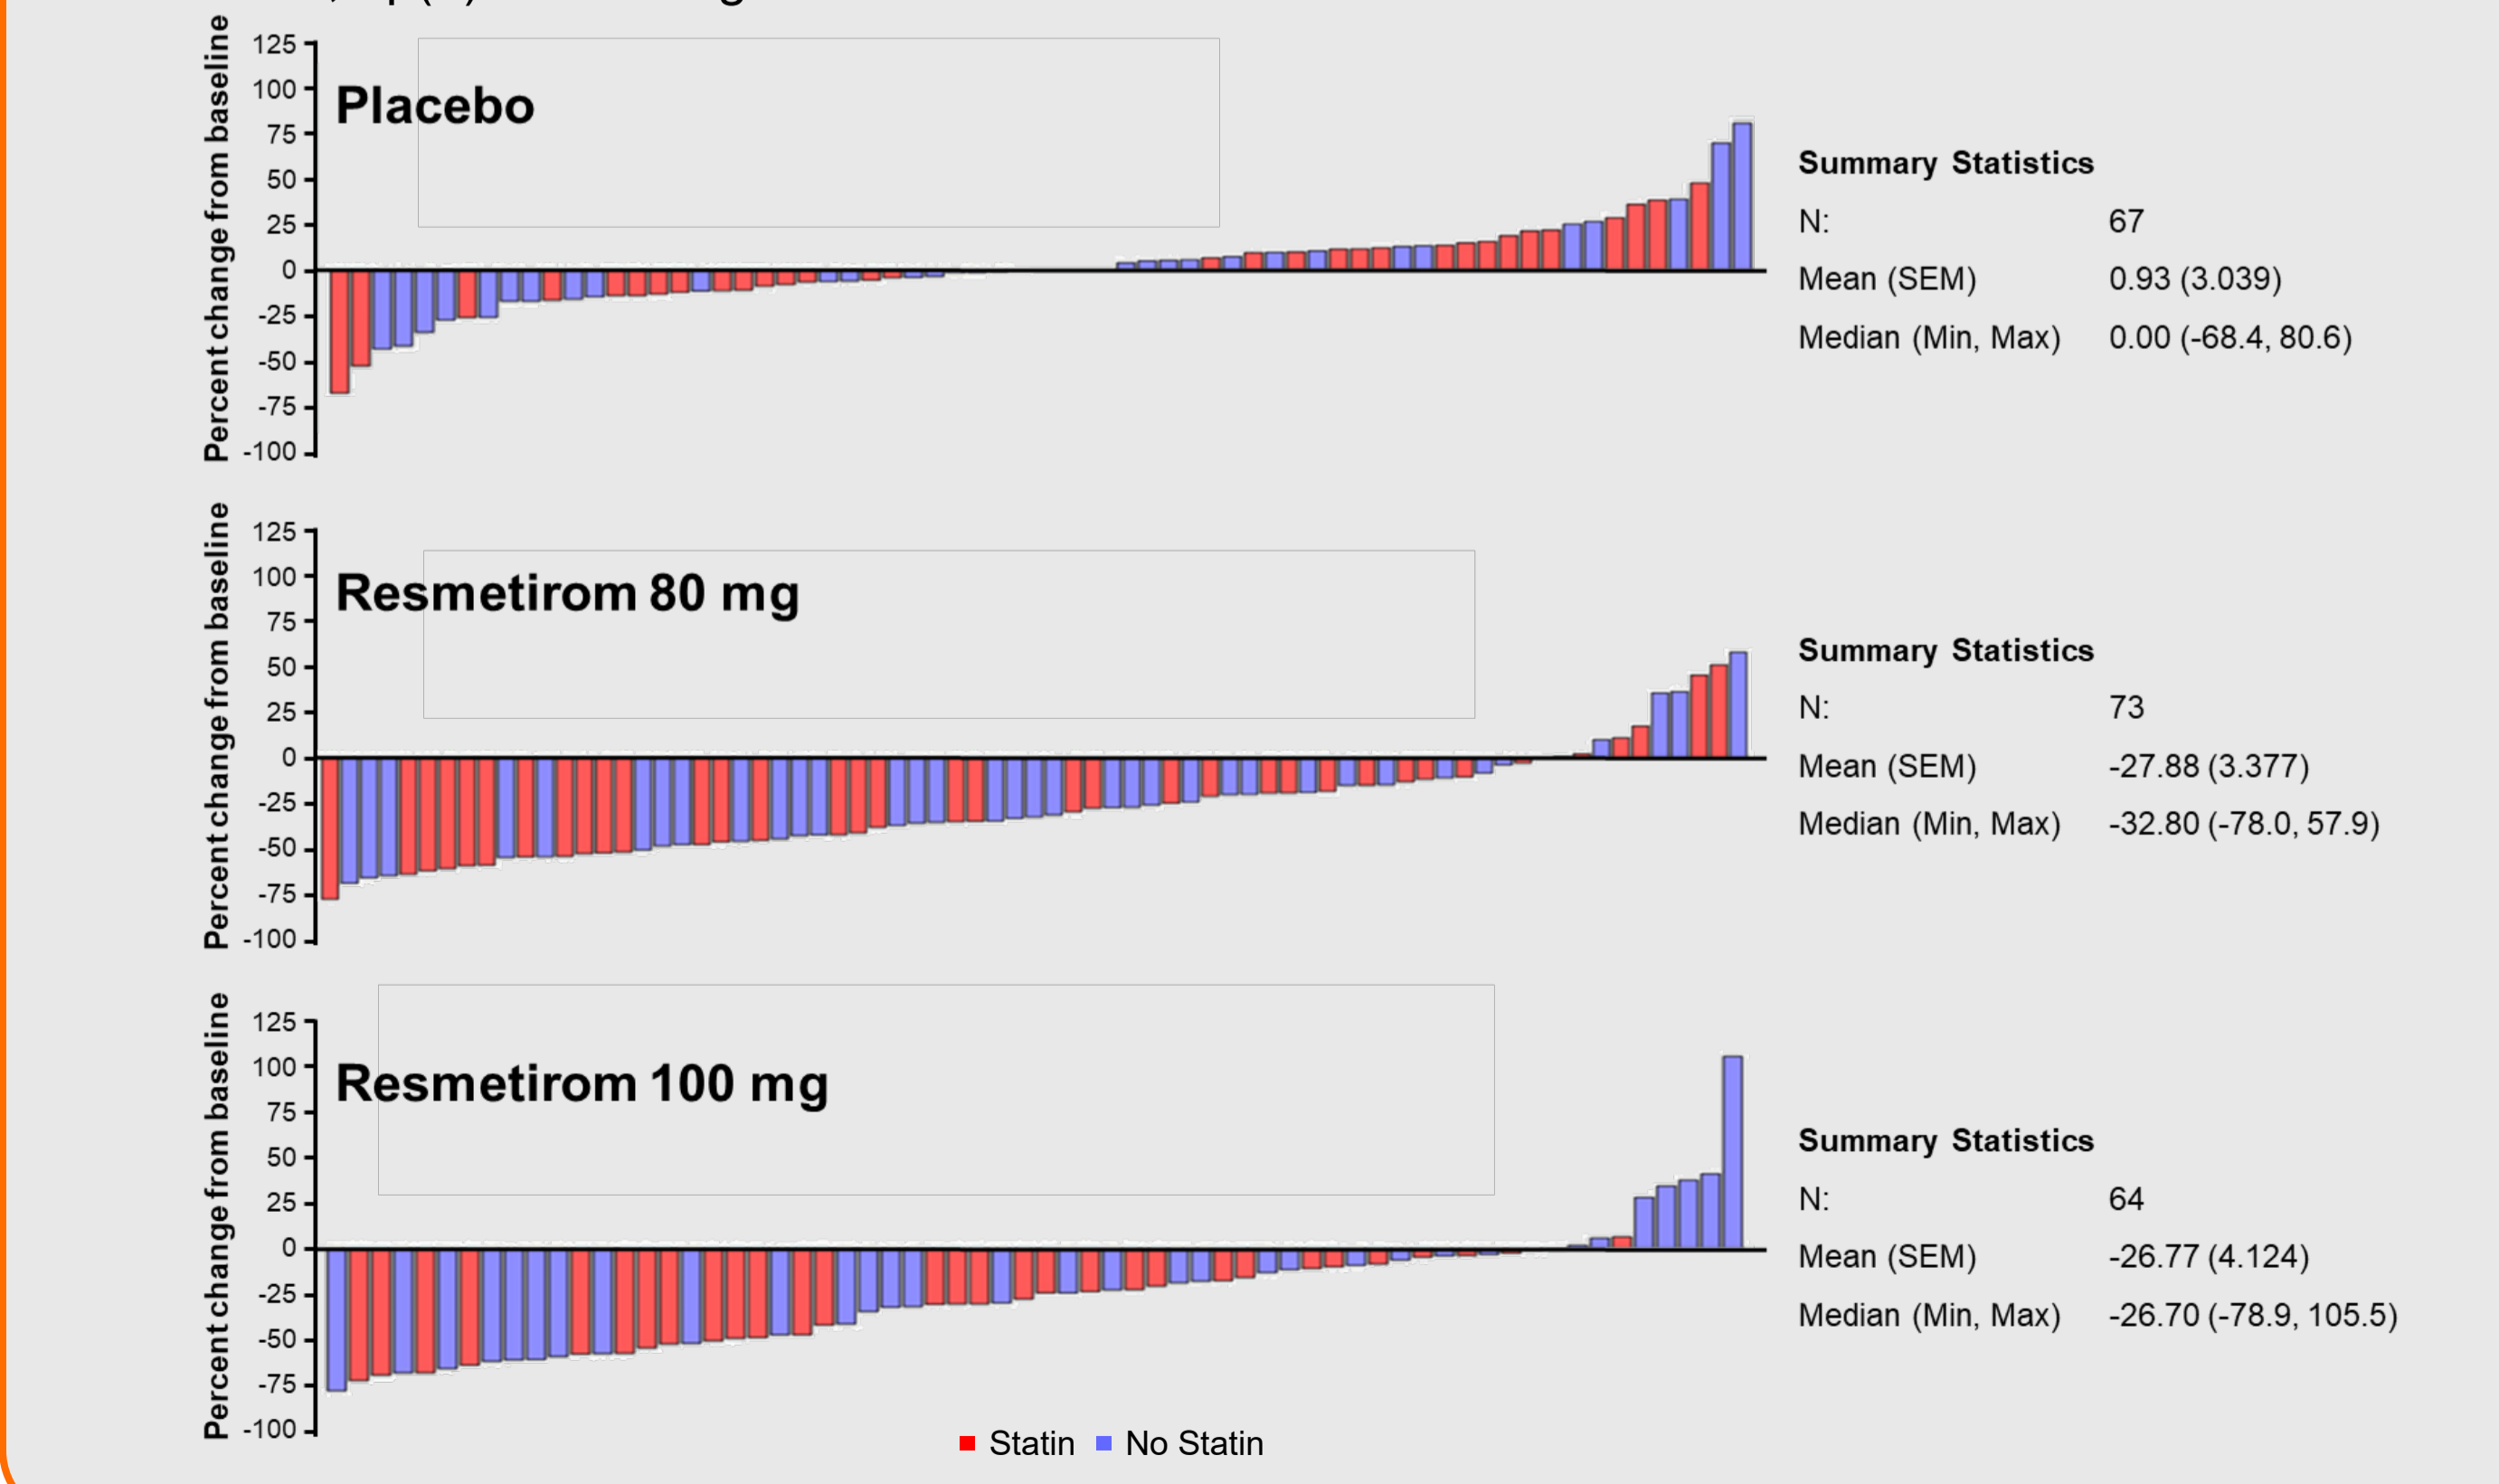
Percentage change from baseline in MRI-PDFF (Week 52, % liver fat content) and lipids (Week 24) by baseline statin use
